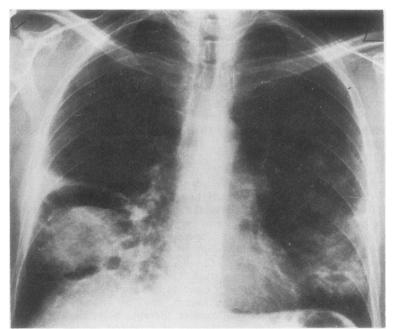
Chest radiograph three weeks later demonstrates lung abscess of the right middle lobe. The abscess contains a large central opacity suggestive of mycetoma.
